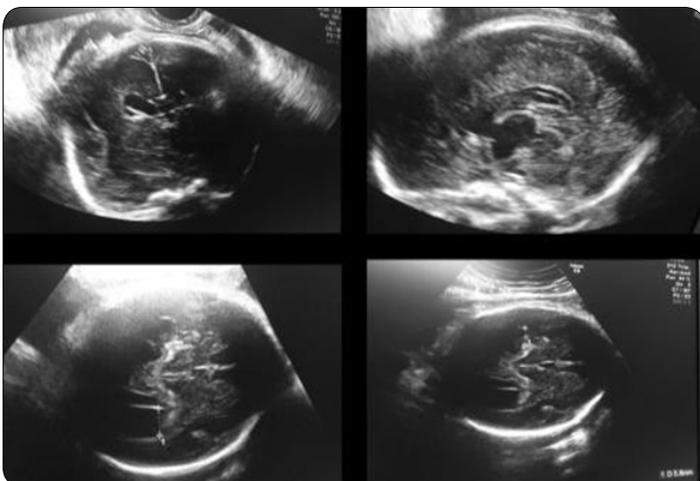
Fetal ultrasound at 32 and 35 gestational weeks: monolateral ventriculomegaly.
